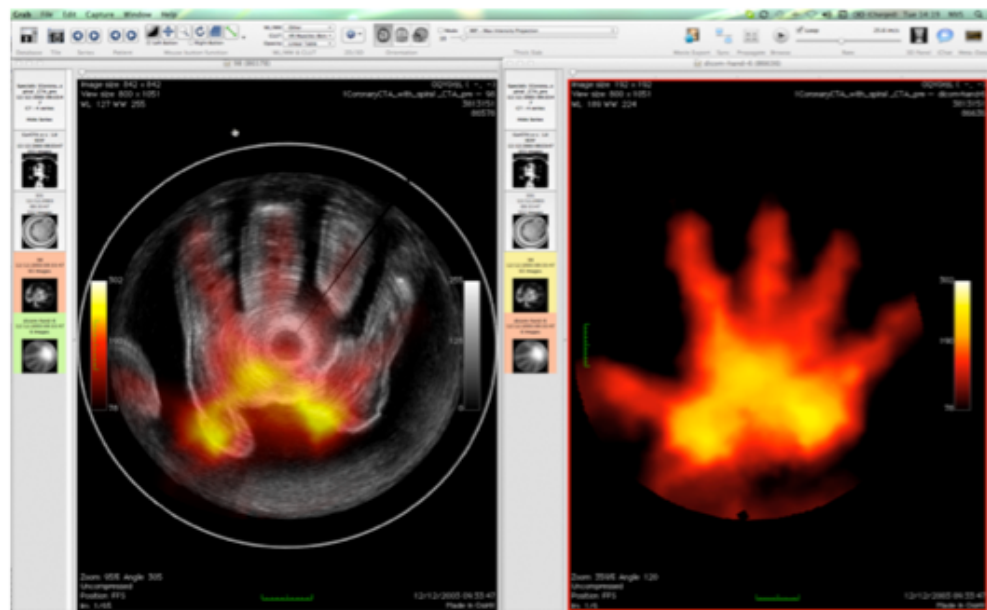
DIACOM image merger, visualisation and thresholding of ultrasound and EIM scans (left); EIM only data (right).
